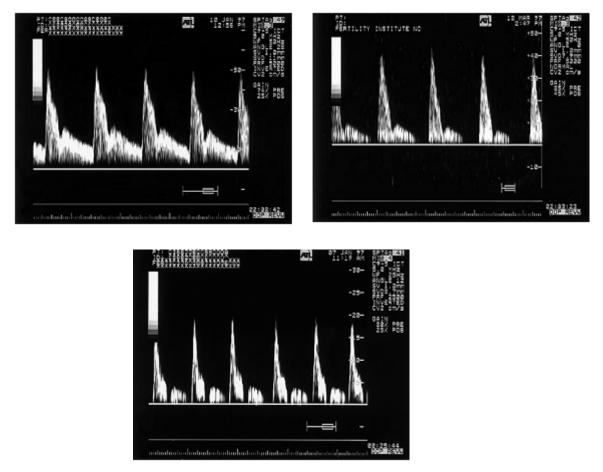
ultrasound flow velocity waveform of uterine artery a-b-c
